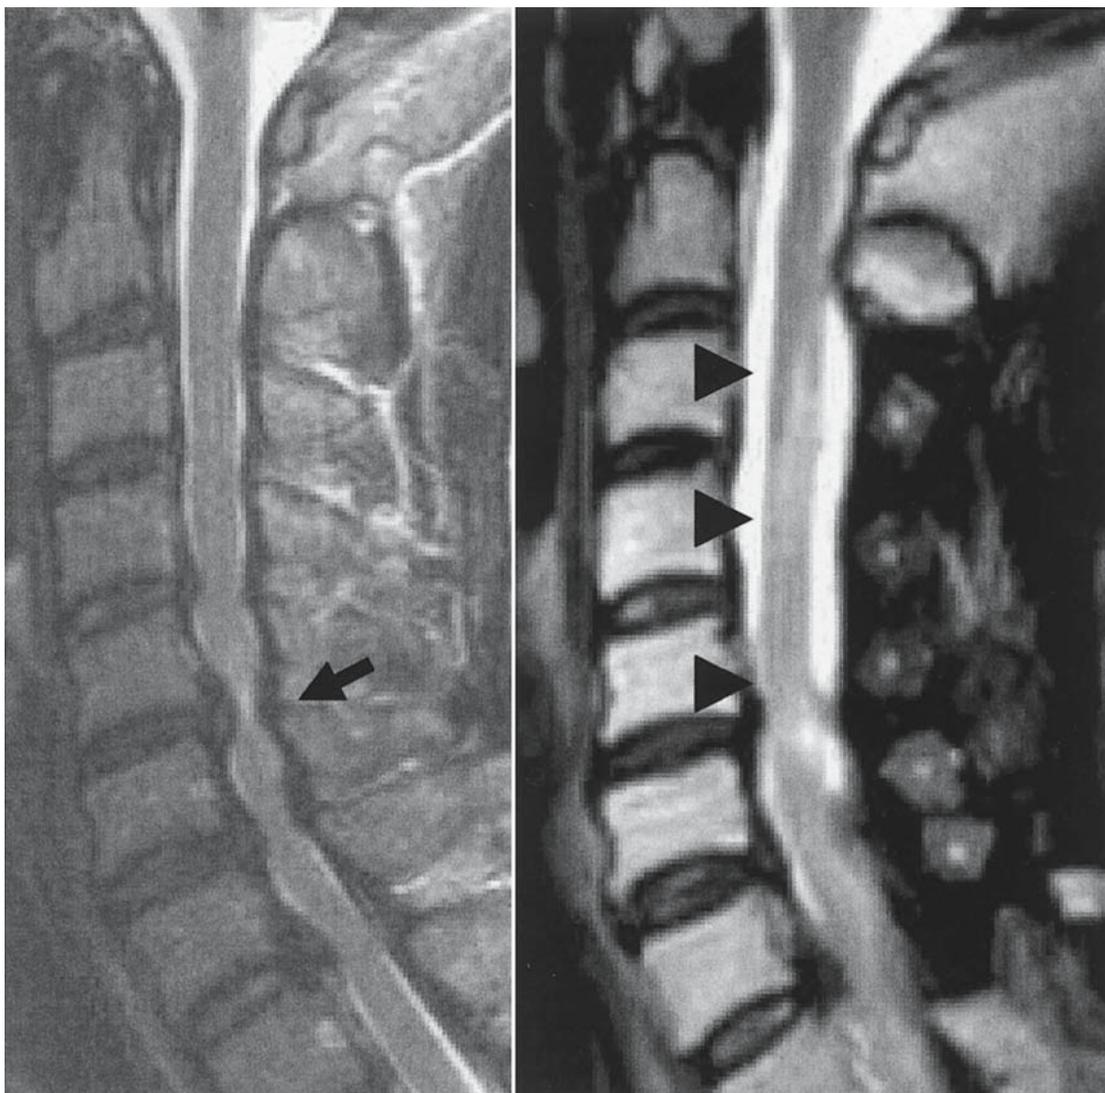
Preoperative (*left*) and postoperative (*right*) T2-weighted MR images of a 57-year-old woman with OPLL who developed postoperative abnormal expansion of an intramedullary high-intensity area. Preoperative T2-weighted magnetic
